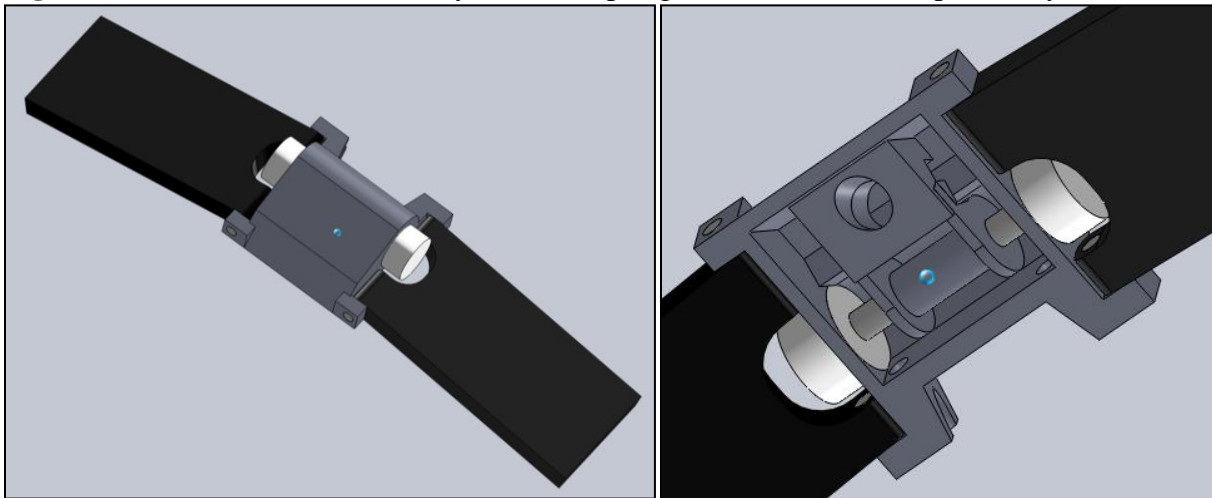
final assembly (without springs or ultrasound transparent layer on bottom)
